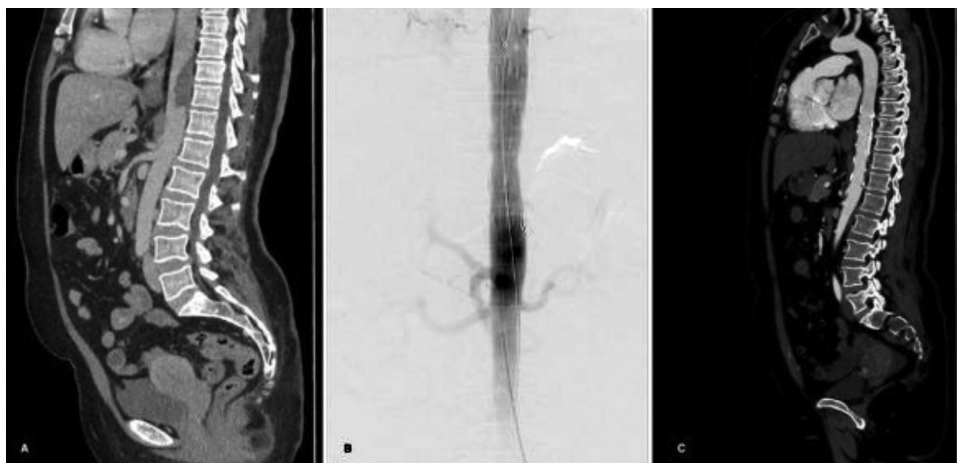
(A) Preoperative sagittal view of the computed tomography angiography demonstrating a large thrombus in zone 5 of the thoracic aorta. (B) Control angiogram of the thoracic aorta following the thoracic endovascular aortic repair. (C) Control computed tomography angiography of the patient at the two-month follow-up.
